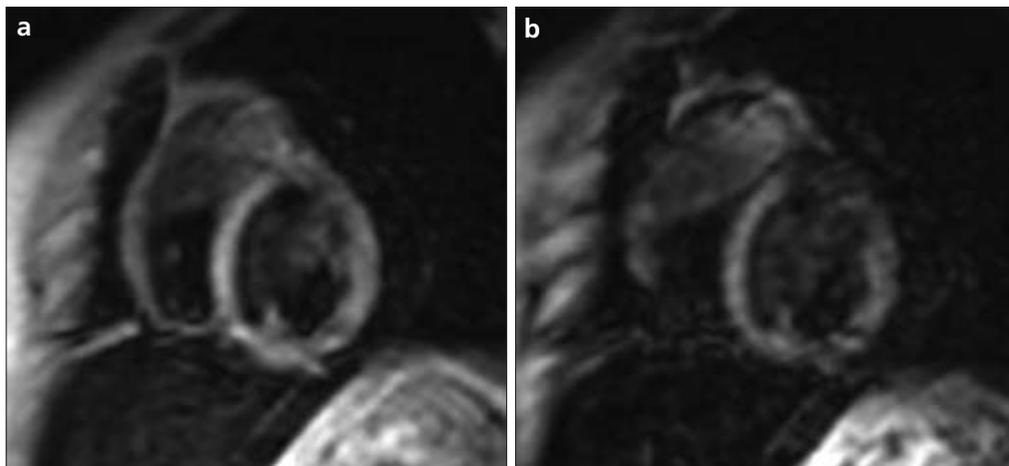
a, b. MR images taken from the short axis midventricular line using black blood dual-echo TFE. TE is either 4.6 ms (a) or 9.2 ms (b).
